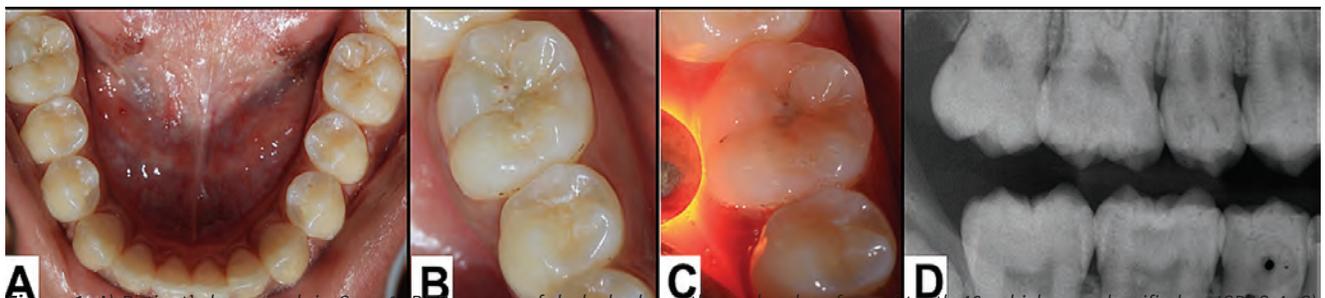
A) Patient's lower arch in Case 1. B) Presence of dark shade on the occlusal surface of tooth 46, which was classified as ICDAS 4. C) Transillumination of tooth 46, confirming dentin involvement in the carious lesion. D) Bitewing radiography of the region, evidencing carious lesion in tooth 46.
